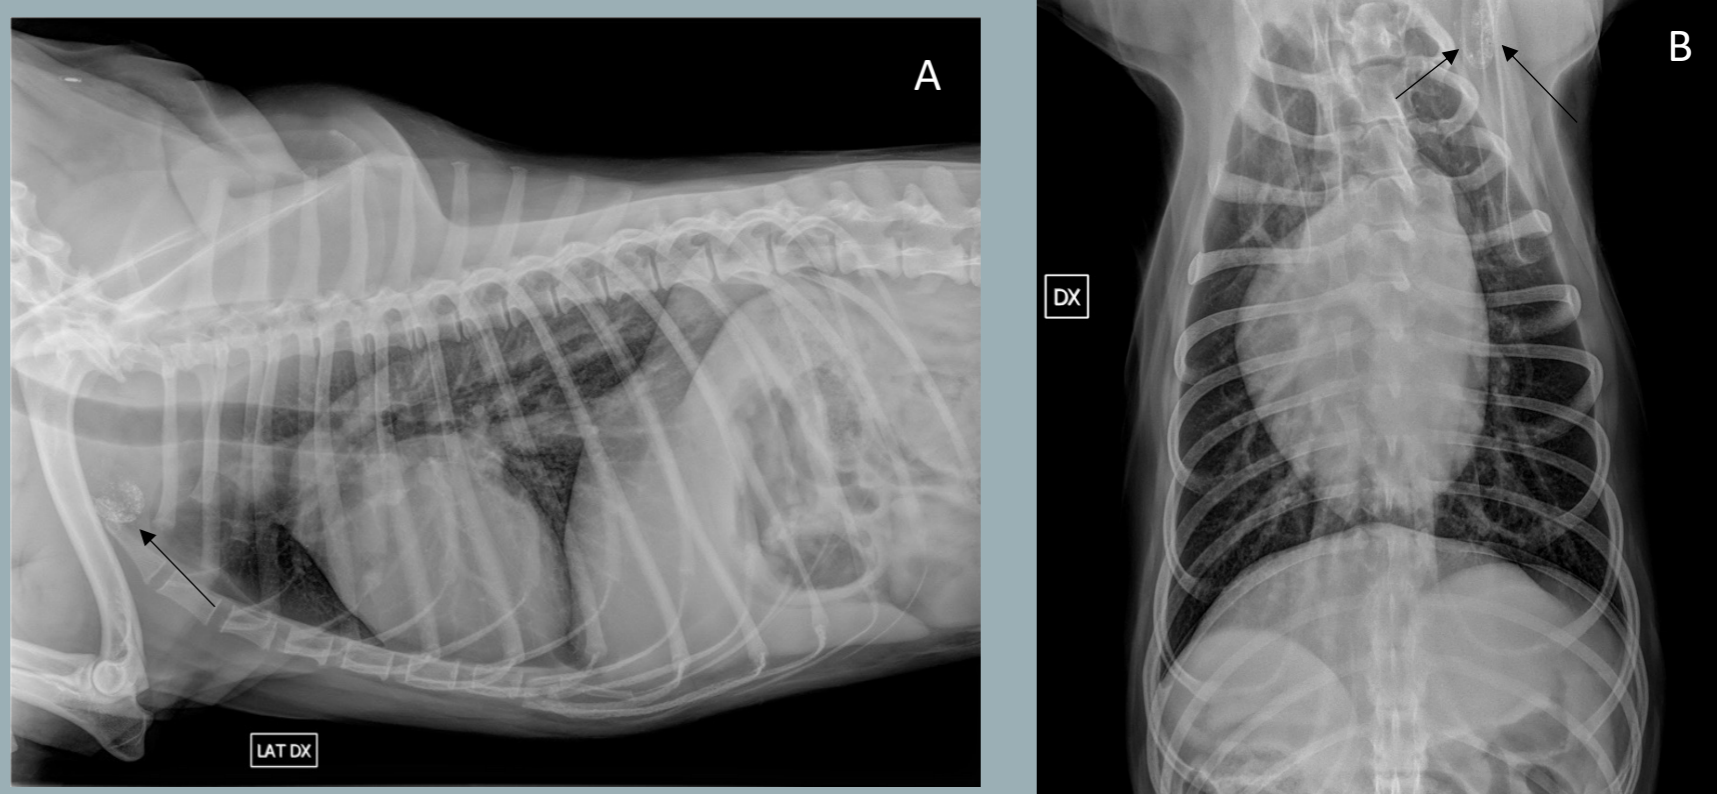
Radiographic indirect lymphangiography 24 hours post Lipiodol of a MCT in the left abdominal wall. (A, B) right lateral and VD view of the thorax. The left axillary SLN is highlighted by the *black arrow*;
